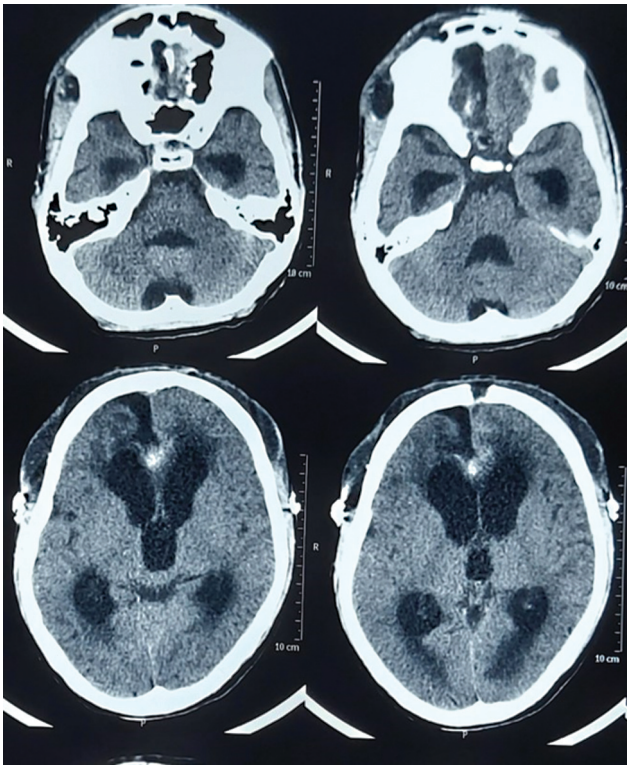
Postoperative noncontrast computed tomography scan showed dilatation of bilateral lateral, third and fourth ventricles, suggestive of communicating hydrocephalus.
